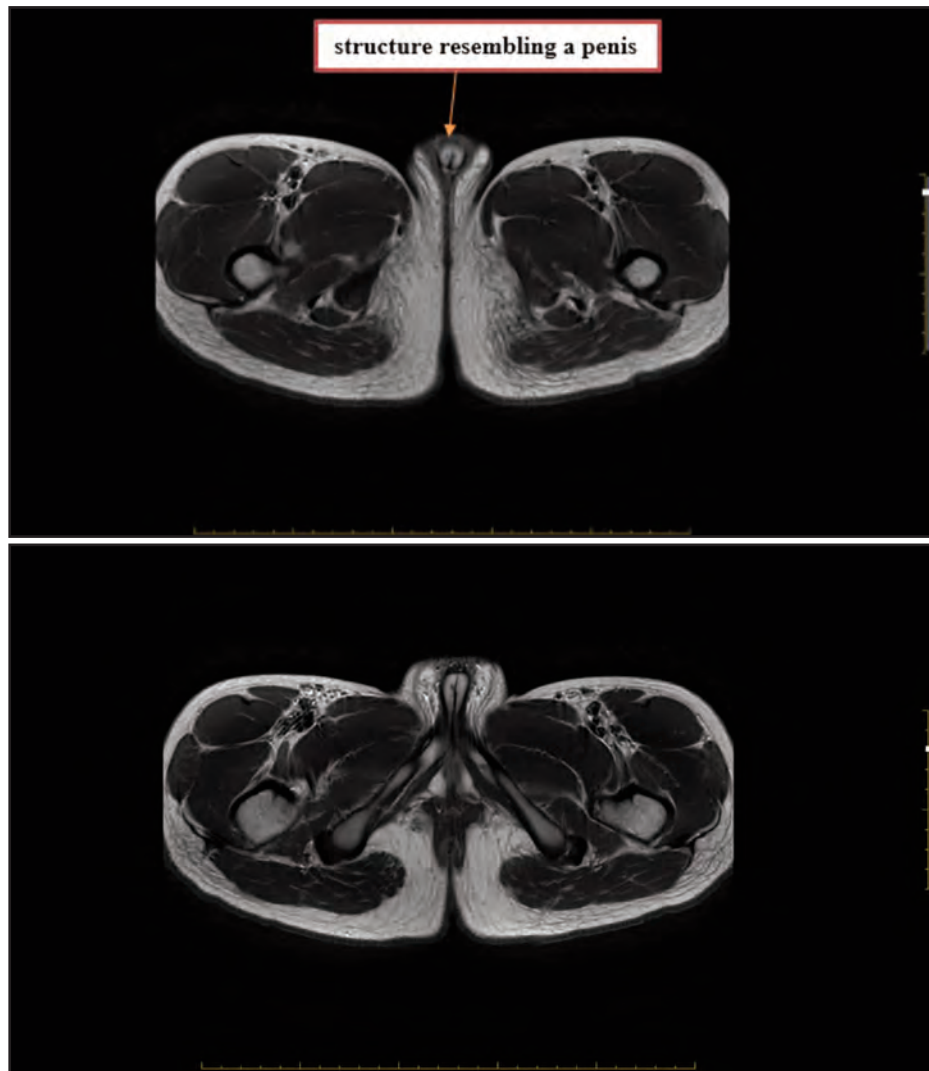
Axial T2-weighted MRI: Demonstrates a structure resembling a penis and non-visualisation of both ovaries
